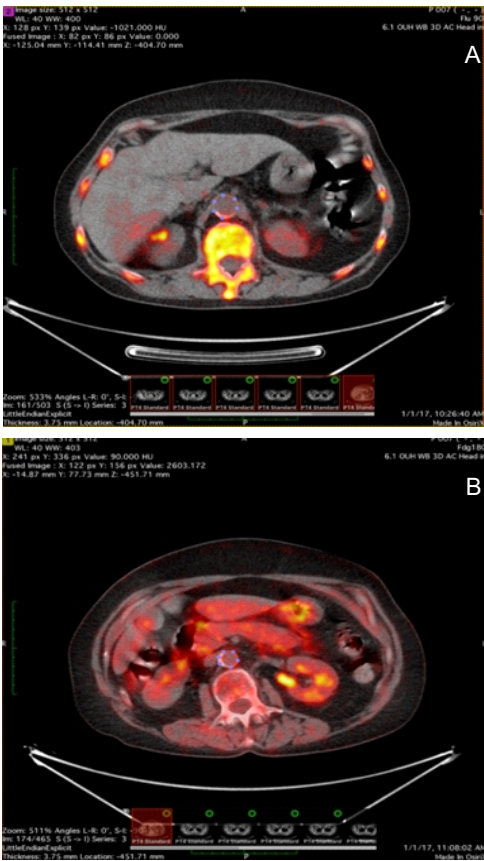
Region of interest (ROI) placement. One transverse slice of fused ¹⁸F-NaF PET/CT (A) and ¹⁸F-FDG PET/CT (B) images at the level of the abdominal aorta. The ROI is drawn around the abdominal aorta (dotted blue circumference in both A and B), and the software calculates the area of the ROI in mm² and the SUVmean within that ROI, which actually represents a volume equal to the product of the ROI area and the slice thickness
